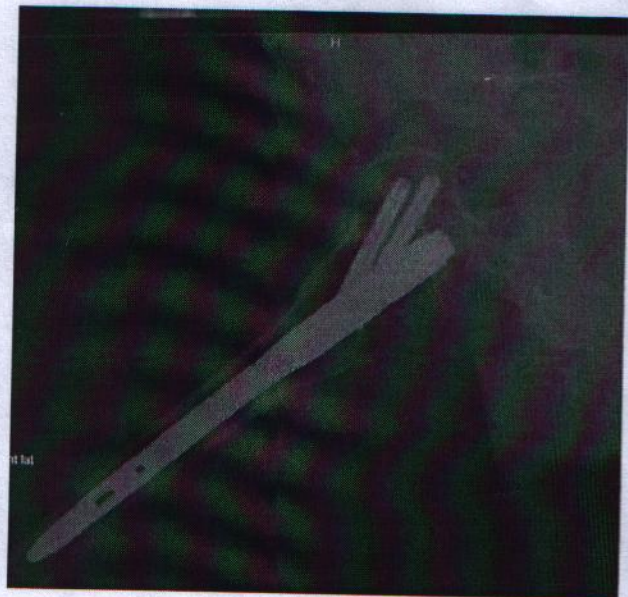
Postoperative lateral roentgenogram of the patient 16 months after treatment with the proximal femoral nail
